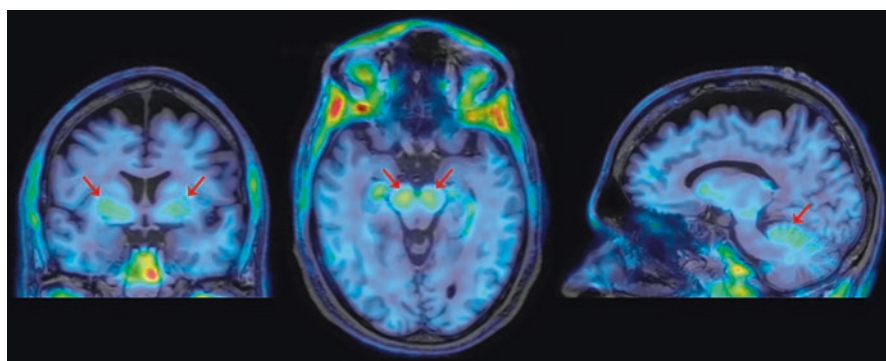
“Nonspecific” uptake with the PET tau tracer ^{18}F -florataucipir. From left to right and projected on MRI, coronal, axial, and sagittal ^{18}F -florataucipir images from a cognitively normal 72-year-old man. Note uptake in the globus pallidus (coronal section, white arrows), substantia nigra (axial section, arrows), and superior portion of the cerebellum (sagittal section, arrow). None of these areas are known to harbor tau
